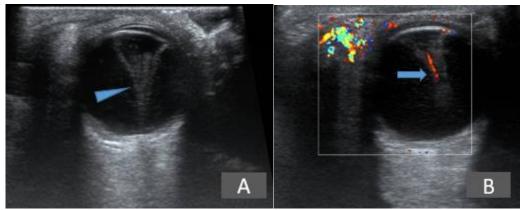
A: B-mode ultrasound showed an echogenic mass in the posterior segment extending from the posterior lens surface to the optic disc without intra-lesional calcification (arrowhead). B: Doppler ultrasound showed the presence of hyaloid vasculature (arrow)
